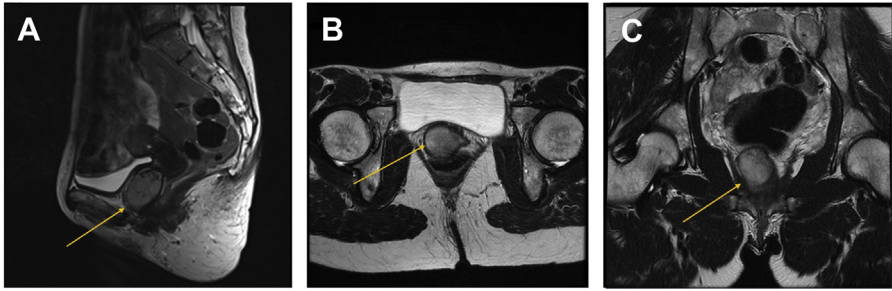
(A–C) Pelvic MRI showing bulky vaginal melanoma (arrows) contained within the vaginal canal.
